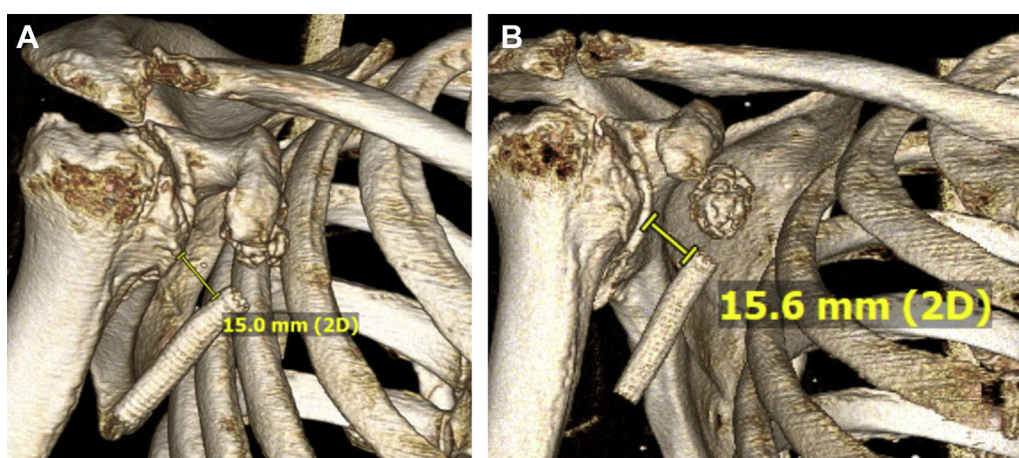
Three-dimensional rendered image of a computed tomographic scan before reverse total shoulder arthroplasty revision. (A) Distance between the humeral cut and the axillary artery stent. (B) Distance between the anterior glenoid rim and the axillary artery stent.
